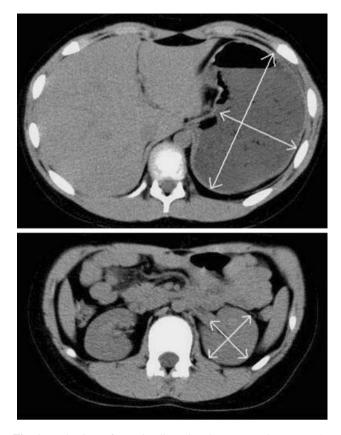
Evaluation of gastric distension in computed tomography (CT). Maximal anteroposterior and transverse diameters of the stomach at the level of the gastric fundus are compared with those of the left kidney at the renal vein level (*arrows*)
